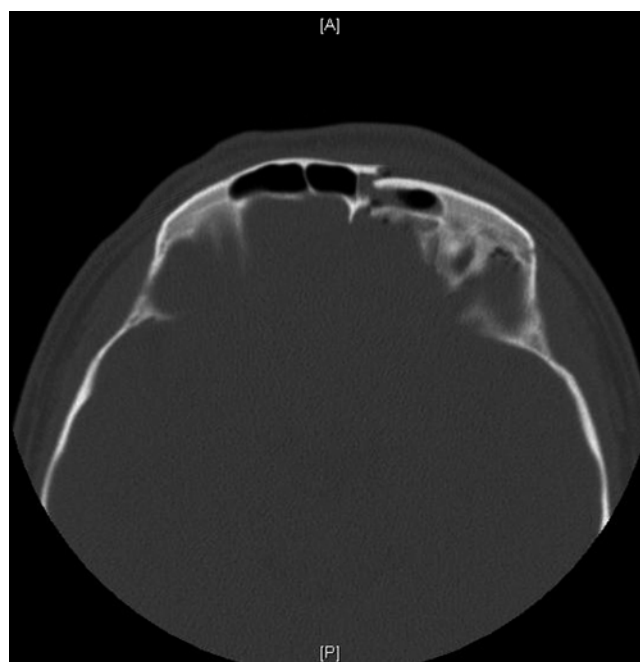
Axial computed tomographic image of a patient with displaced anterior and posterior table fractures, pneumocephalus, and sinus opacification
